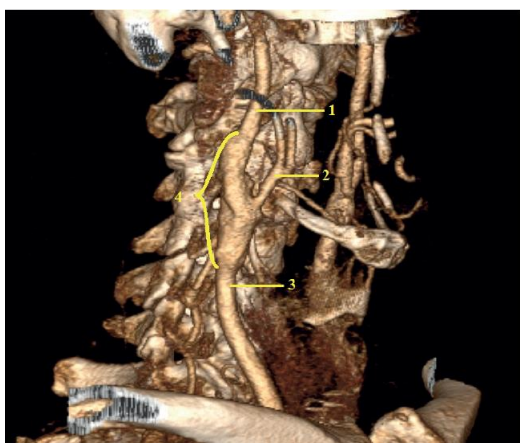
Multislice computed tomography with angiography of the brachiocephalic arteries: 1 — internal carotid artery; 2 — external carotid artery; 3 — common carotid artery; 4 — patch implantation area.
